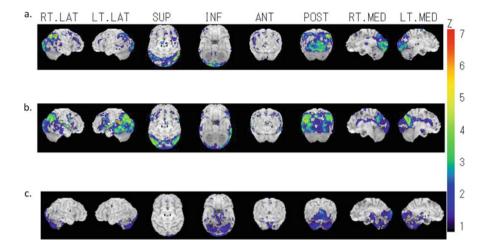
(a–c) FDG-PET findings in DLB. Using three-dimensional stereotactic surface projection (3D-SSP) analysis with an age-matched normative database (77 normal healthy volunteers between 41 and 84 years of age [36 men and 41 women]), we evaluated the decrease in the regional cerebral metabolic rate of glucose for each patient. (a) Probable DLB. A case with cerebral hypometabolism with limited involvement of the primary visual and visual association area. Hypometabolism in the temporoparietal association area; pattern is almost preserved. In such cases, cognitive impairment is not prominent during the early stage of its clinical course. (b) Probable DLB. In addition to the primary visual and visual association area, these types of cases show cerebral hypometabolism in the posterior cingulate cortex, cuneus, precuneus, and temporoparietal association cortex. In such cases, cognitive impairment is prominent in the early stage of the clinical course. (c) DLB-MCI. In addition to primary visual and visual association area, cerebral hypometabolism is detected in the cerebellum
